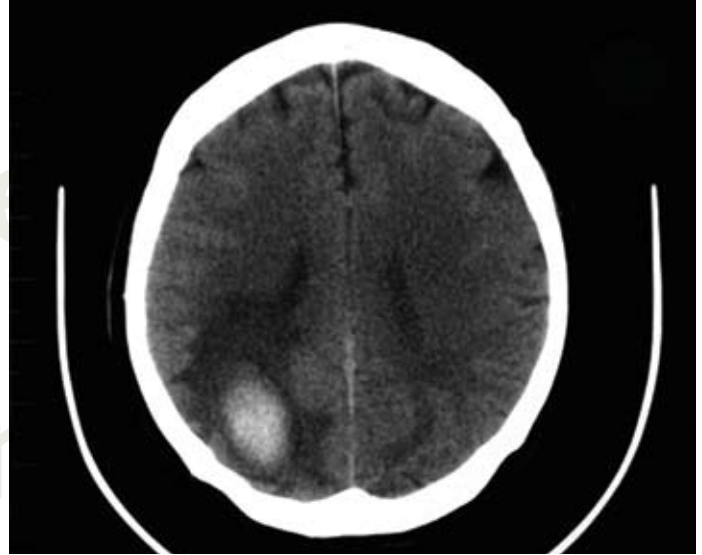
Repeat CT scan two weeks after presentation demonstrating significant resolution of the haematoma
